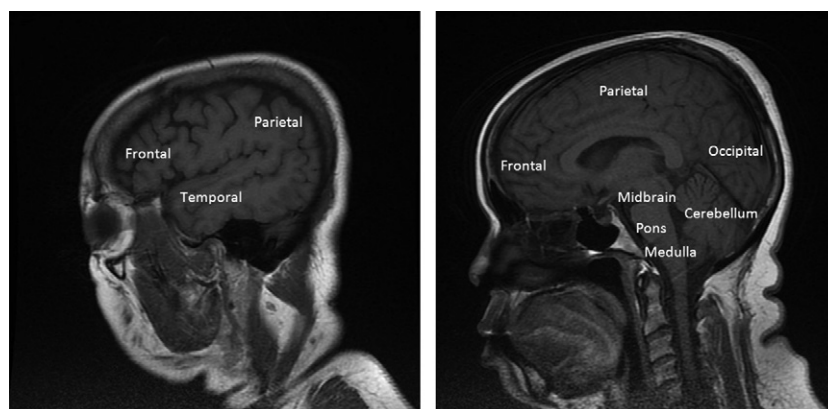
T1-weighted sagittal images demonstrating the major intracranial central nervous system tissue divisions. The brainstem, composed of the midbrain, pons, and medulla, is located in the posterior fossa with the cerebellum; this space is also referred to as the infratentorial space. The supratentorial space houses the lobes of the cerebral hemispheres and is divided right from left by the falx cerebri. The anterior fossa contains the frontal lobes and the middle fossa contains the temporal lobes; these 2 fossae are separated by the sphenoid ridge.
